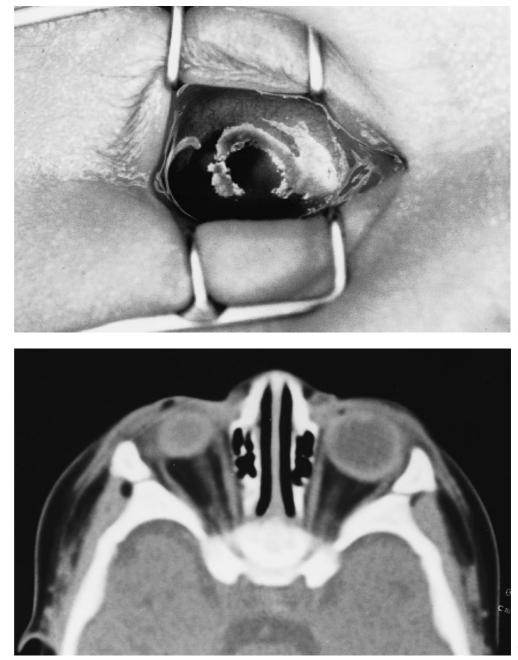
a Microphthalmia and corneal opacity (right eye). b Computed tomography of the orbit
